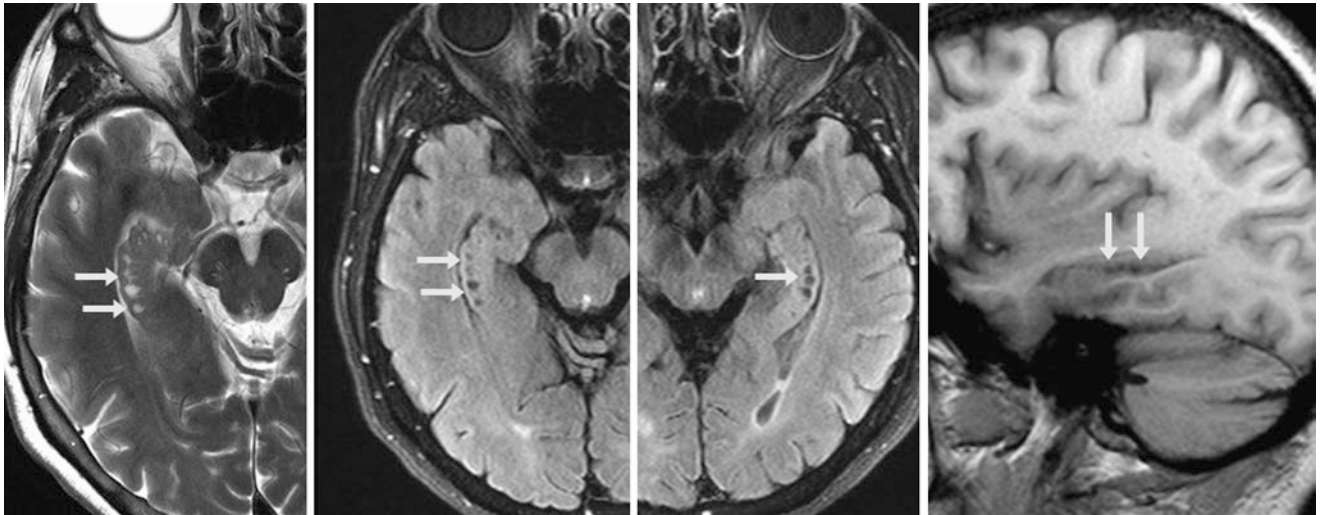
A 69 year old with a 3 T MRI that shows multiple right hippocampal cysts (*arrows*) on axial T2WI (*left*) and on FLAIR (*left middle*). They are also noted on the left side on FLAIR (*right middle*) and on sagittal T1WI (*right*)
